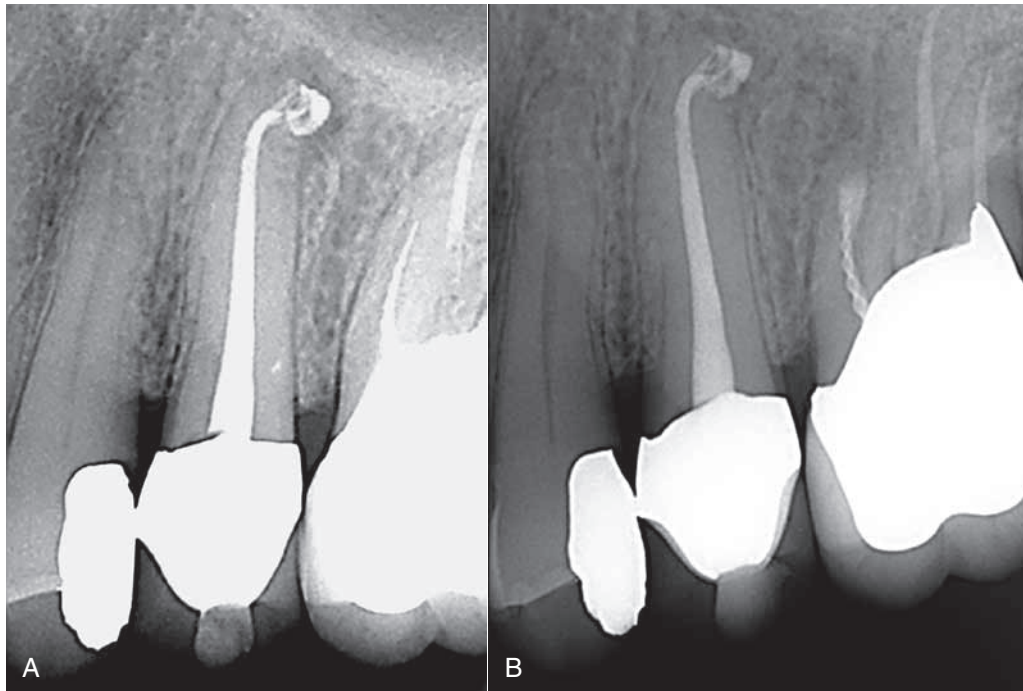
A, Resilon/Epiphany cone root canal system obturation. B, Recall radiograph taken 8 months after initial treatment shows complete healing. (Courtesy Dr. Richard Rubenstein, Farmington Hills, MI.)
